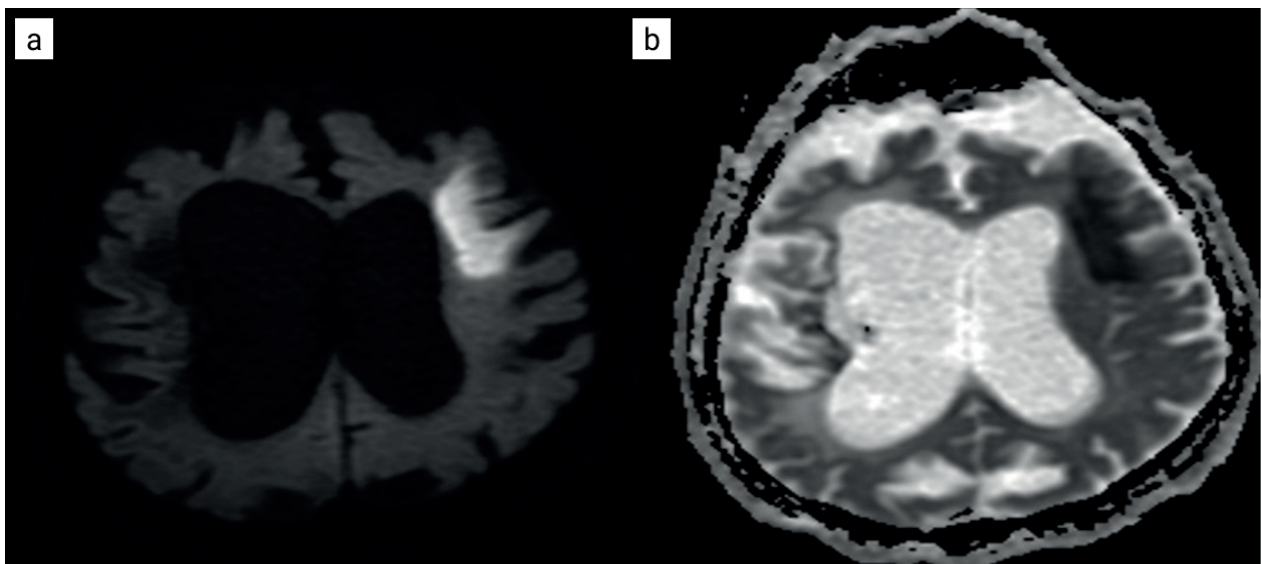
The DWI scan shows a left-sided hyperintensity in the frontal lobe (a), which can be appreciated as a hypointensity on the ADC trace map (b).
